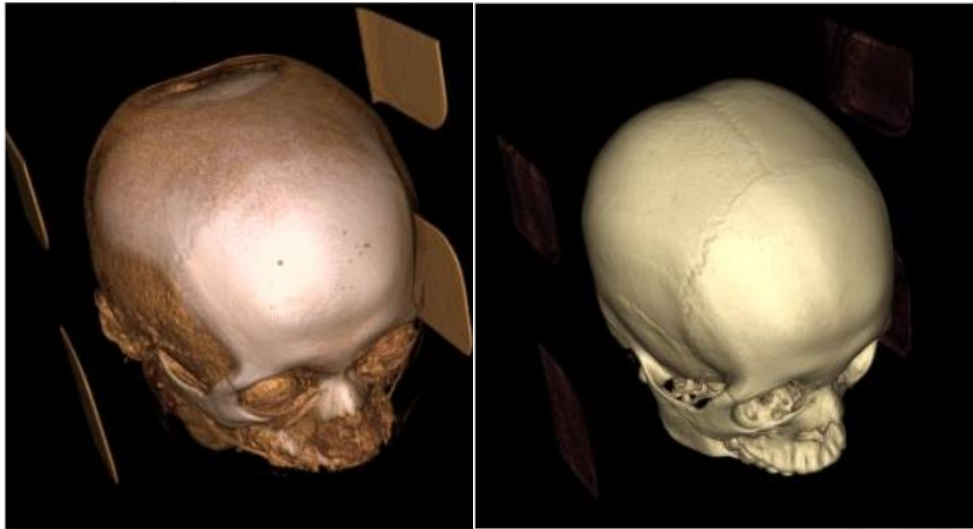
14 CT Head Image with Volumetric Rendering. the left one shows before rendering, and rendered on the right.
